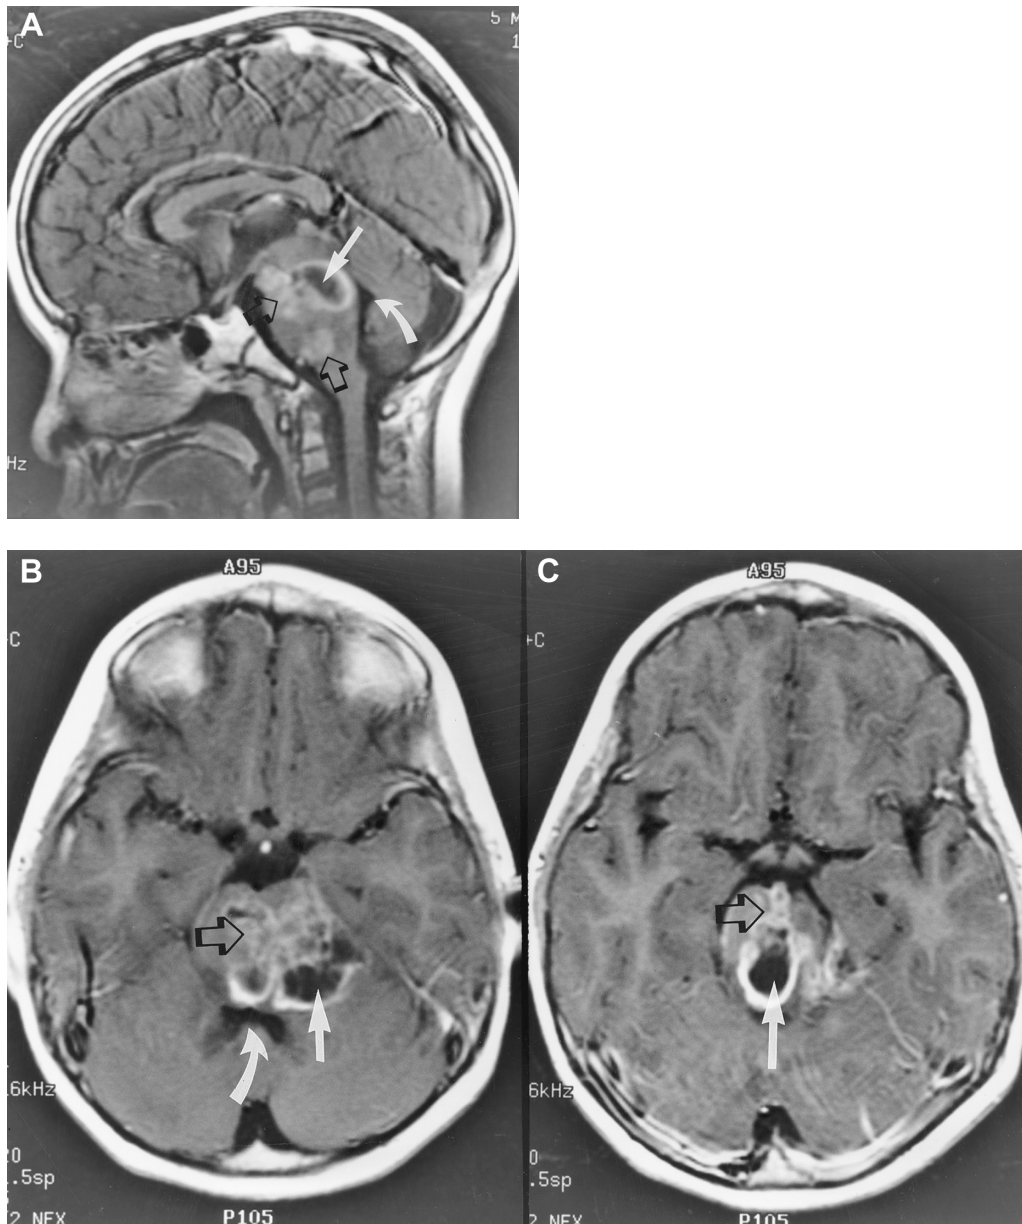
Brain stem astrocytoma. Post-contrast sagittal (A) and post-contrast axial MRI scans at the mid (B) and upper (C) pons. The brain stem is markedly expanded by solid (open arrows) and cystic (white arrows) components of tumor. The IV ventricle (curved arrows in A and B) is displaced posteriorly by the brain stem tumor.
